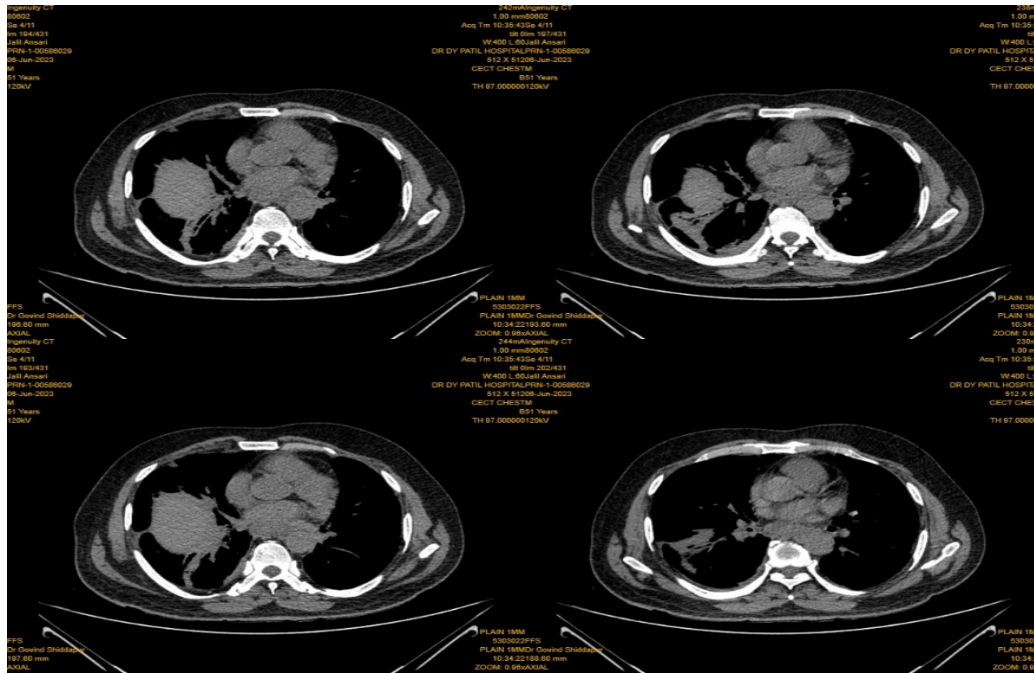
HRCT thorax showed mild bilateral pleural effusion (Right>Left) with few areas of subsegmental atelectasis, circumferential wall thickening of esophagus extending for approximately 15cm from mid thoracic region to gastroesophageal junction
